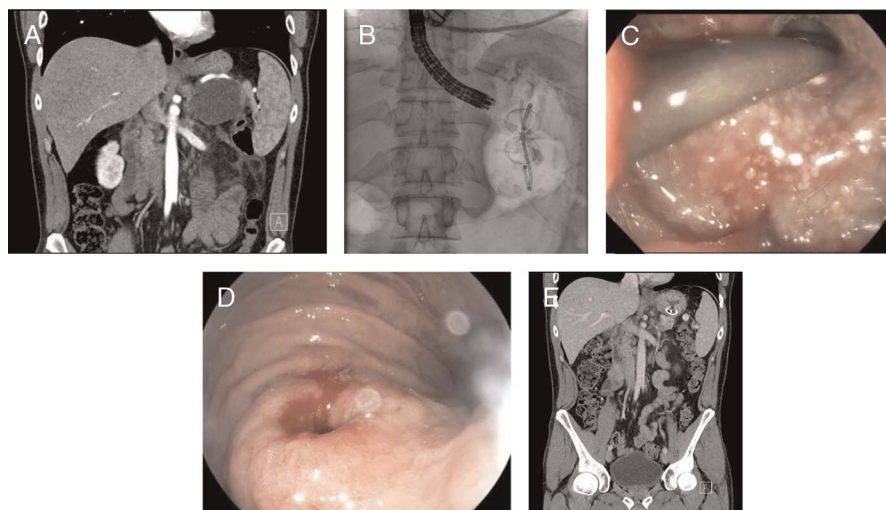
Buried stent syndrome 8 weeks after initial placement. A, Initial CT scan of the infected pancreatic pseudocyst—please note the intercepting vessel because of portal hypertension. B, Placement of the LAMS and an additional plastic double-pigtail stent to increase the drainage effect by avoiding stent obstruction. C, View into the lumen of the buried stent with the double-pigtail stent still in place. D, View of the buried stent after removal of the double-pigtail stent. E, CT scan before stent removal—please note the overgrown proximal stent flange. CT: computed tomography; LAMS: lumen-apposing metal stents.
